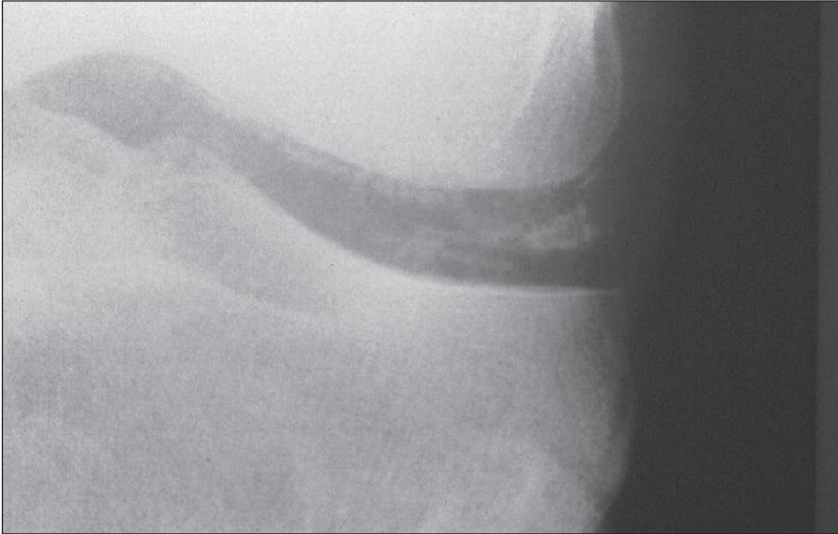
Knee radiograph showing chondrocalcinosis of both fibrocartilage (meniscus) and hyaline cartilage.
